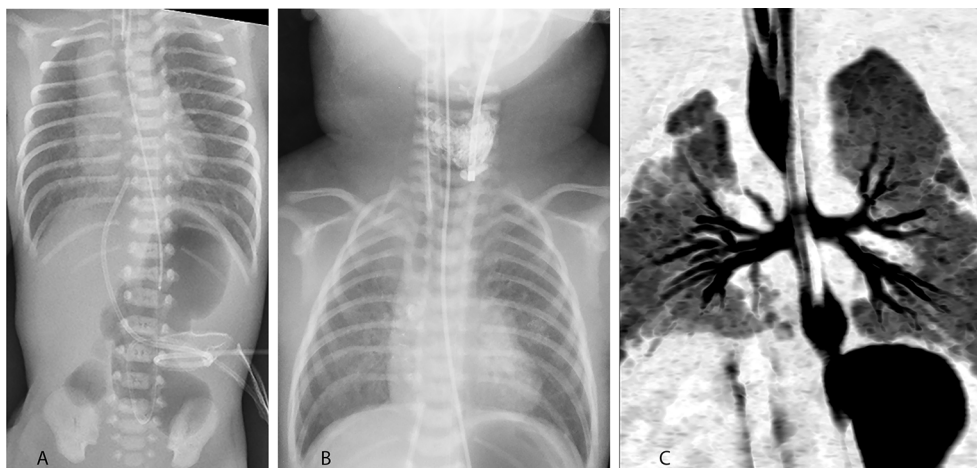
Admission chest X-ray (A) showing absence of tracheal shadow below the tip of the endotracheal tube and very hyperexpanded and hyperlucent lung fields. Subsequent X-ray (B) following instillation of perfluorocarbon radiopaque contrast showing it pooling in the blind ending trachea. CT chest (C) confirming findings of tracheal agenesis; right and left main bronchi appear to arise directly from the oesophagus, from which the stomach also arises below the diaphragm.
